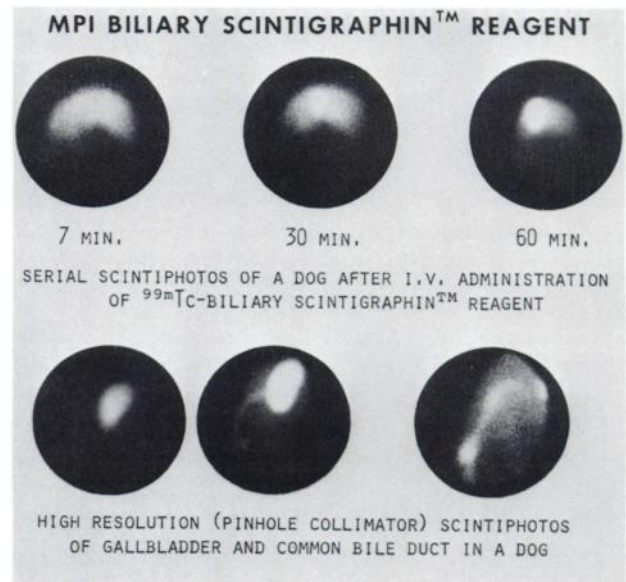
In vivo scintigraphy of ^{99m}Tc -MPI Hepato-Biliary ScintigraphinTM. Upper scintiphotos were obtained using 4,000 parallel-hole collimator, and lower scintiphotos were obtained using pinhole collimator fitted to scintillation camera. Liver is well visualized within 7 min after administration, similar to that seen with ^{99m}Tc colloids except for absence of activity in spleen with ^{99m}Tc -HBS. At 30 min, concentration of activity in gallbladder is clearly noted with such activity becoming prominent at 60 min. By suitable adjustment of image intensity gallbladder (lower left), gallbladder and common bile duct (lower center), and common bile duct alone (lower right) can be imaged with high resolution.
